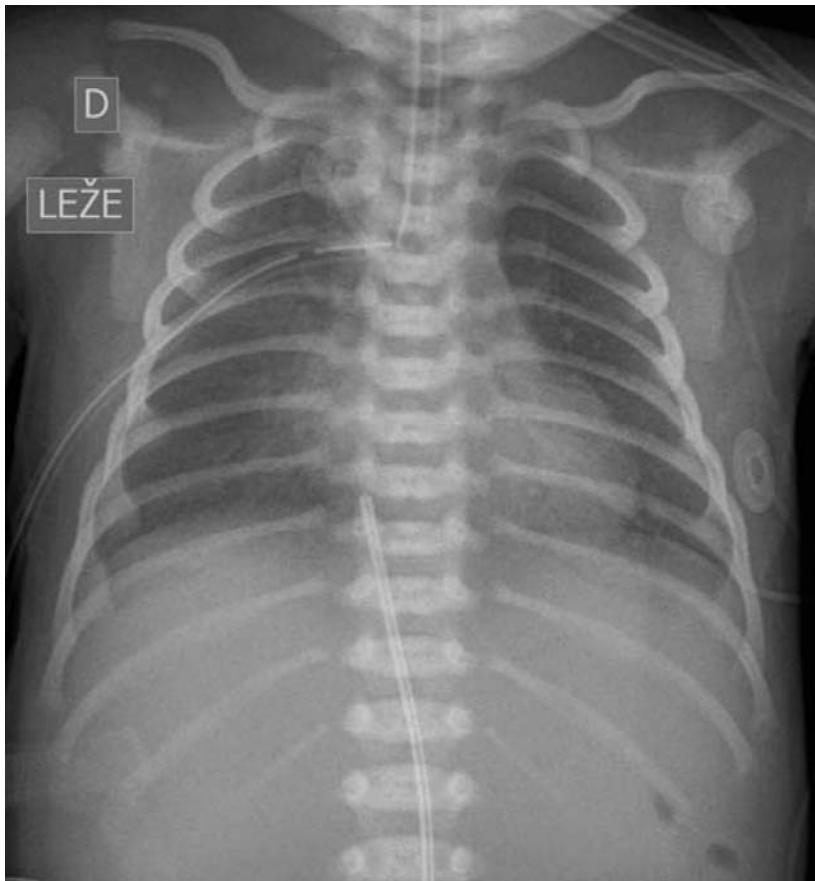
Chest x-ray after insertion of a chest tube in the right hemithorax.
